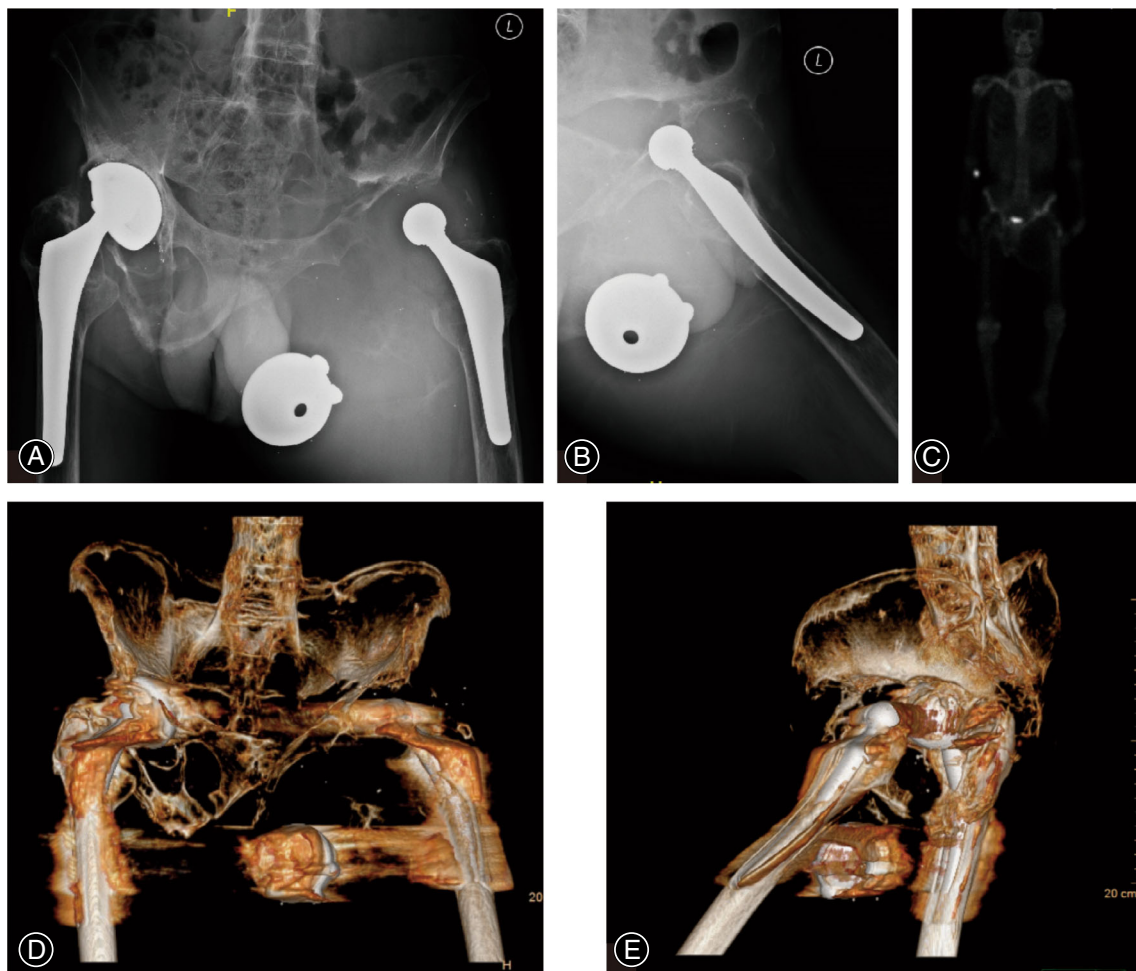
Preoperative radiograph imaging of the pelvis demonstrating periprosthetic osteolysis of left hip. (A) Anteroposterior (AP) radiograph of the pelvis. (B) Lateral radiograph of the left hip. (C) Bone scintigraphy showing no active bone metabolism. (D) 3D reconstruction of CT scan of the pelvis. (E) 3D reconstruction of CT scan of left hip. CT = computed tomography.
